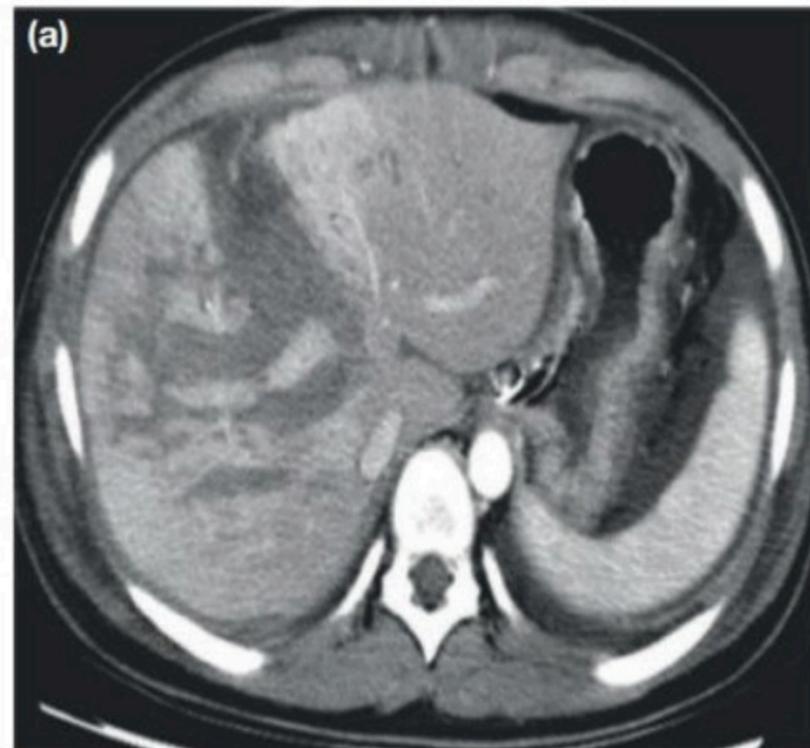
Computed tomography scans demonstrating the significant differences between blunt (a) and penetrating (b) trauma (assault with a kitchen knife).
